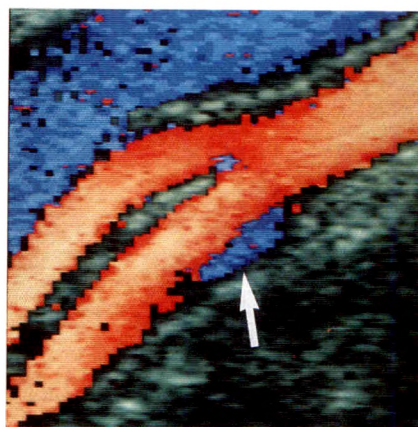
Longitudinal sonogram of carotid bifurcation obtained during systole. Physiologic flow reversal is in proximal internal carotid artery (arrow). This typically occurs in posterior lateral aspect of lumen away from takeoff of external carotid artery. Notice that systolic streamline flow in proximal internal carotid artery is eccentric.
